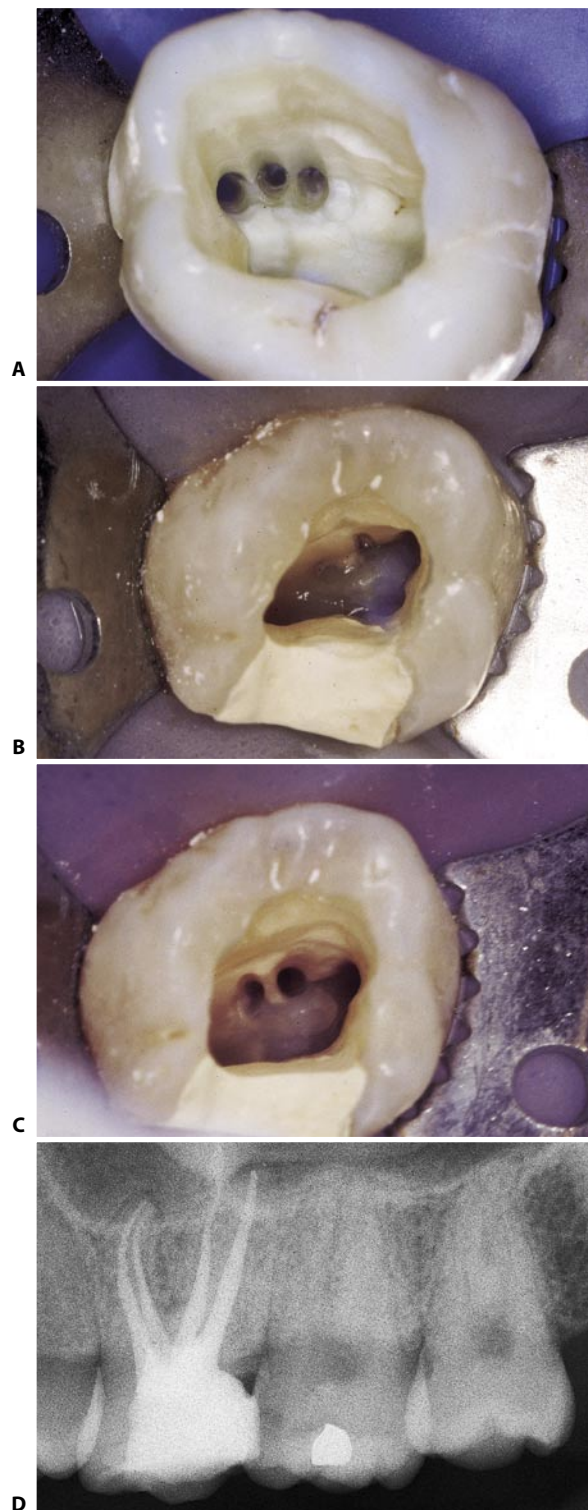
A. The access cavity of this extracted molar shows three canals in the mesiobuccal root. B. Careful examination of the access cavity of this upper molar shows the presence of a third opening near the orifice of the mesiopalatal canal. C. The three canals have been cleaned and shaped. D. Postoperative radiograph: MB2 and MB3 were joining together.
